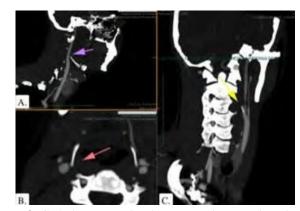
CTA demonstrated a close contact between the enlarged right posterior horn of the hyoid bone and the right ICA. A and C, sagittal view. B. Axial cut of the CT scan. (*Purple arrow*: posterior horn of the hyoid bone, *red arrow*: relationship between ICA and ECA, *yellow arrow*: communication between the hyoid bone and ICA).
